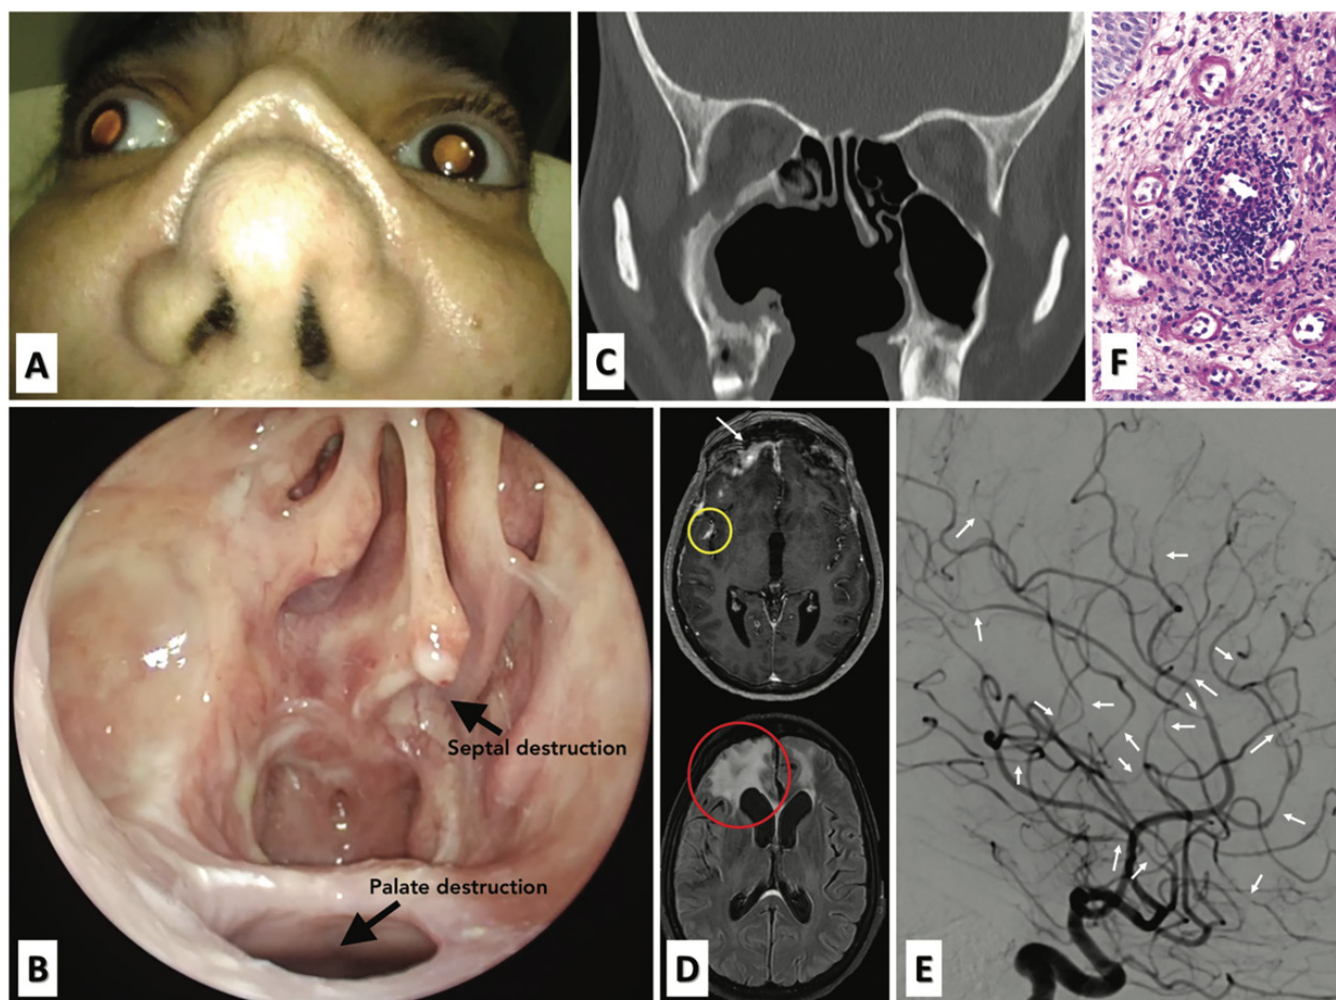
A) Marked saddle nose due to an extensive destruction of nasal osteocartilaginous septum. B) Massive palate and septal destructive lesions by nasal endoscopy. C) CT showing complete midfacial bone/cartilage and right maxillary sinus destruction. D) (Upper) post-contrast axial T1-weighted image showing frontal pachymeningeal thickening and enhancement (arrow) associated with leptomeningeal enhancement in the Sylvian fissure (yellow circle), and (Down) axial fluid-attenuated inversion recovery (FLAIR) image showing frontal acute/subacute ischaemic areas (red circle). E) Right internal carotid artery digital subtraction angiography (DSA) showing multiple stenoses predominantly in medium vessels from the right anterior and middle cerebral arteries (arrows). F) Nasal biopsy disclosing perivascular and transmural lympho-monocytic inflammation of a small nasal artery with vessel wall necrosis and chronic inflammation of the nasal tissue.
